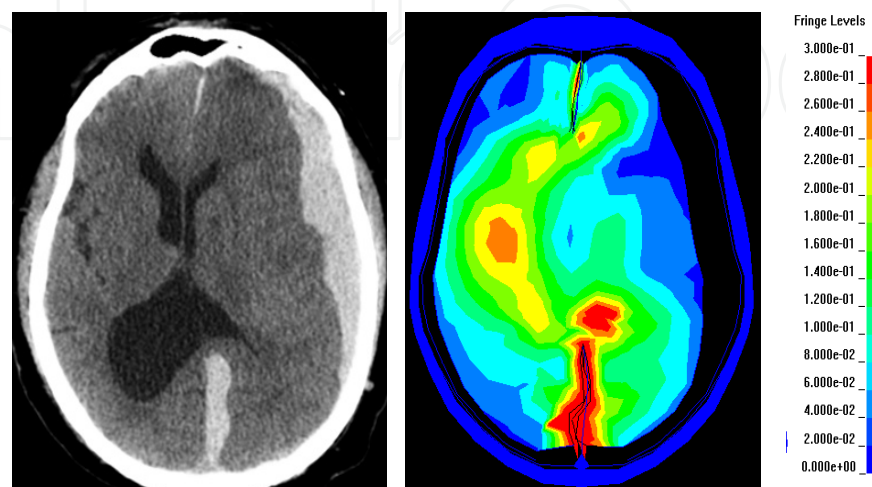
CT verified subdural haematoma (left) evaluated with NIBIE and strain level (right).
